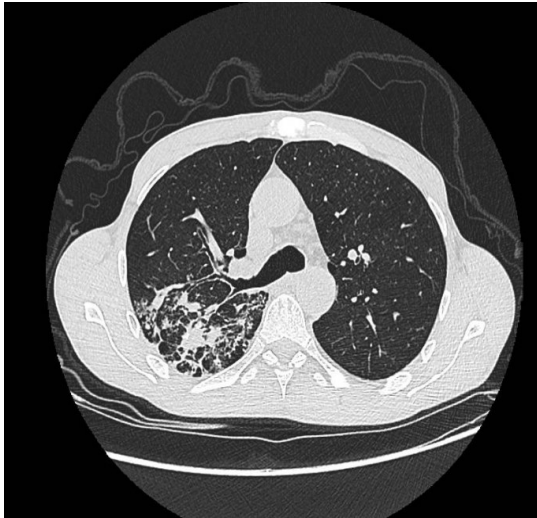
Chest CT scan: tree-in-bud pattern
